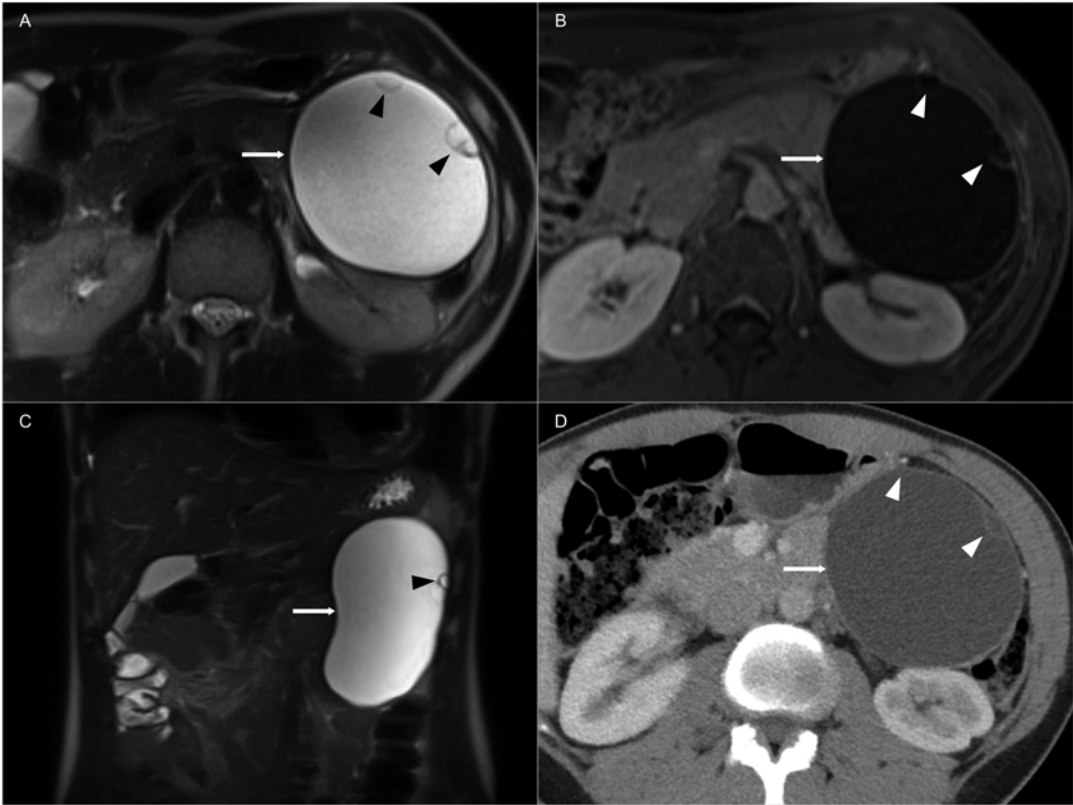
Typical imaging findings of a female patient with a large mucinous cystic neoplasm at the pancreatic tail on MRI (a–c) and CT (d). The lesion (*arrow*) is unicellular with homogeneous content and two mural nodules
